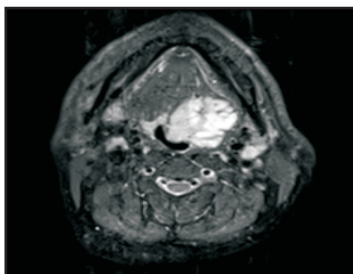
T2W MRI showing enhancing lesion in left BOT
